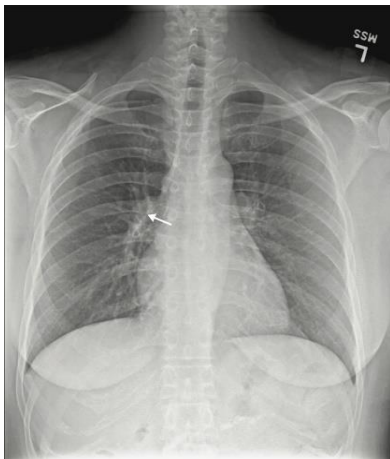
Pre-operative chest radiograph with an incidental pulmonary artery stent (marked by arrow).
